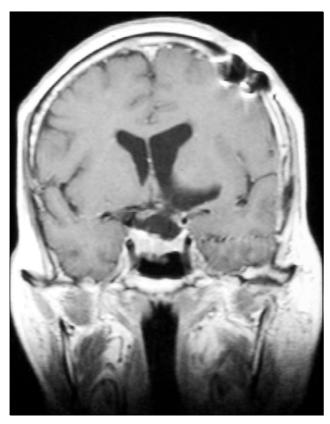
Postoperative coronal T1-W MRI shows no residual or recurrent lesion. The left lateral ventricle has regained its normal size and place.
